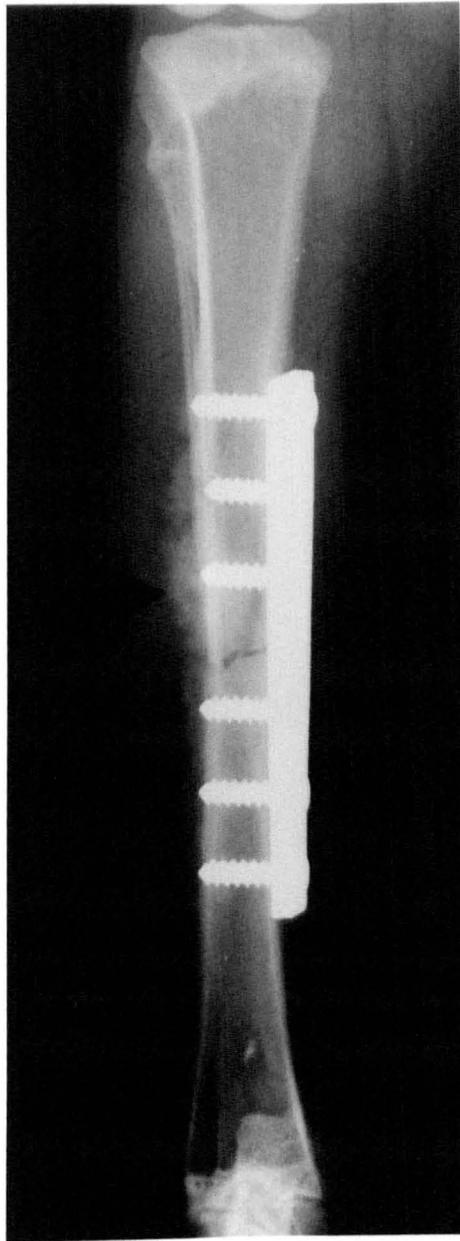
Radiograph obtained two weeks after fixation with a dynamic compression plate and inoculation with bacteria. There is marked immature periosteal reaction laterally and the fracture line is visible.
